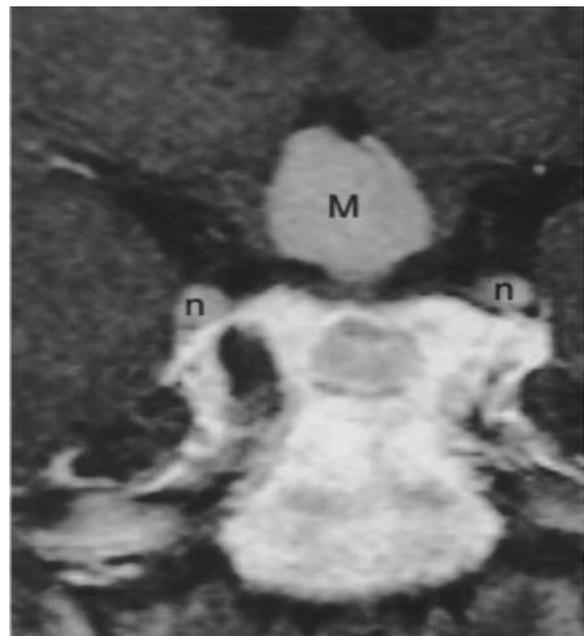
Coronal MRI, T1 sequence with intravenous contrasted agent showing an enhancing mass (M) in the floor of third ventricle and enlargement of both trigeminal nerves (n) which also show post contrast enhancement.
